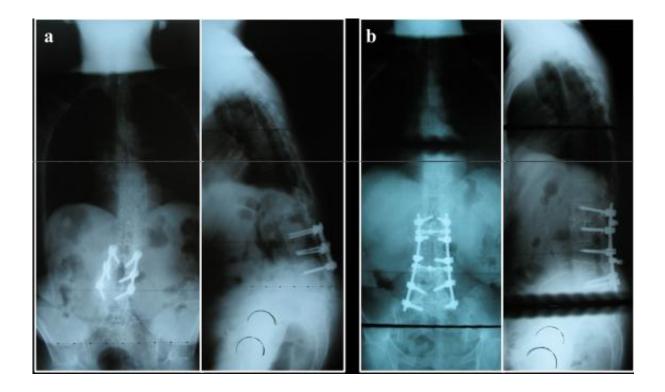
(a) Plain erect radiographs of a 68-year-old lady presenting with back pain and radicular leg pain. She had previous posterior decompression and posterolateral fusion.
